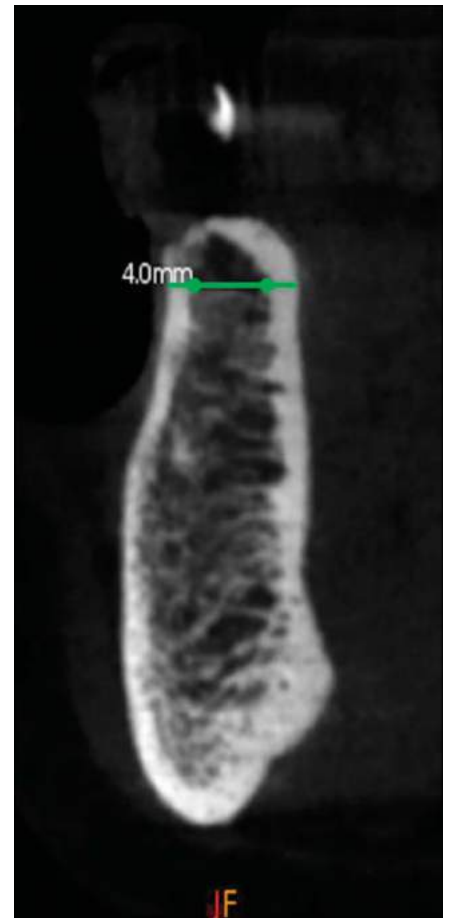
Cone-beam computed tomography cross-section view depicting an example of the recommended minimum ridge for plastic expansion with osseodensification: 4-mm width with ≥ 2 mm trabecular bone core and 1-mm cortical plate thickness.
